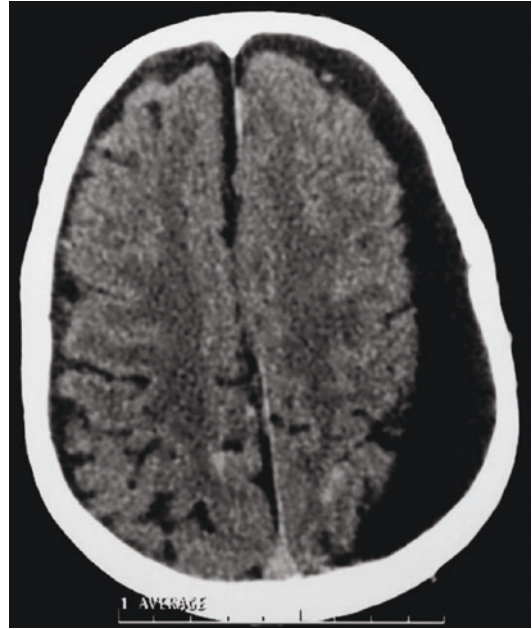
Axial CT scan image showing a left frontal subdural hygroma
